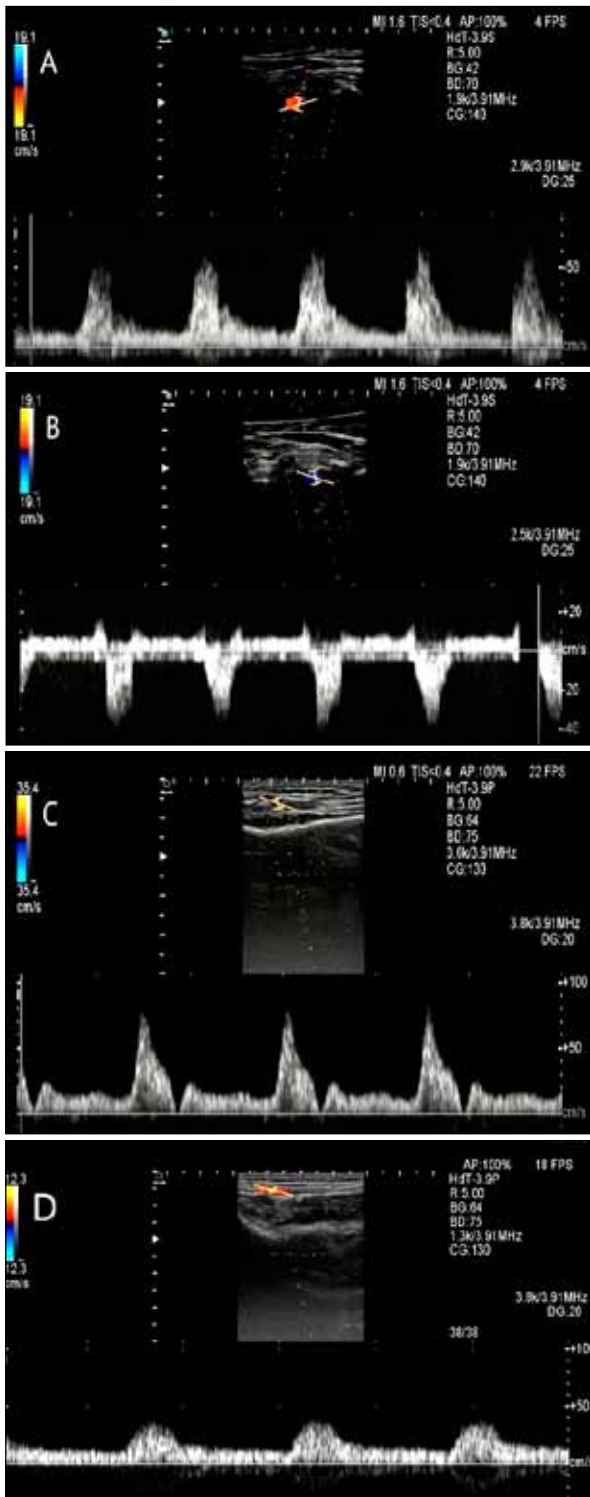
Doppler flow spectrum in radial and vertebral arteries. A – Right vertebral artery. B – Retrograde flow in the left vertebral artery. C – Right radial artery. D – Reduced flow in the left radial artery.
